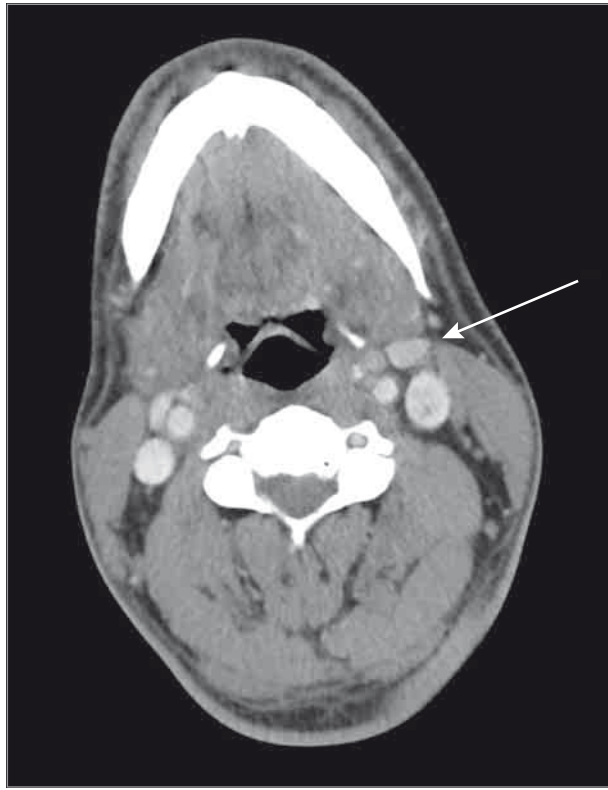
Case 1: Computed Tomographic (CT) Scan
